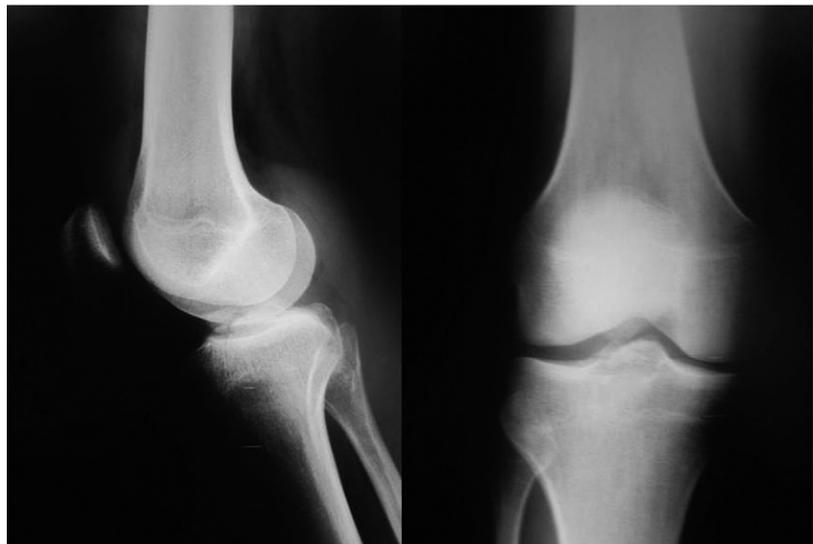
Anteroposterior and lateral radiographs of type III tibial eminence fracture.
